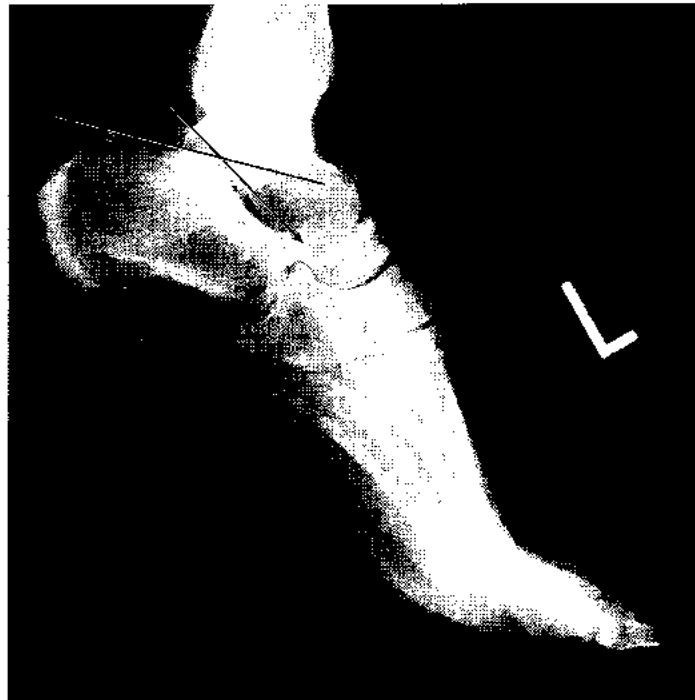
(right) Böhler's angle as seen on a lateral radiograph of the foot and ankle. Loss of this angle implies loss of the appropriate articulation of the subtalar joint at the posterior, anterior, and middle facets.
